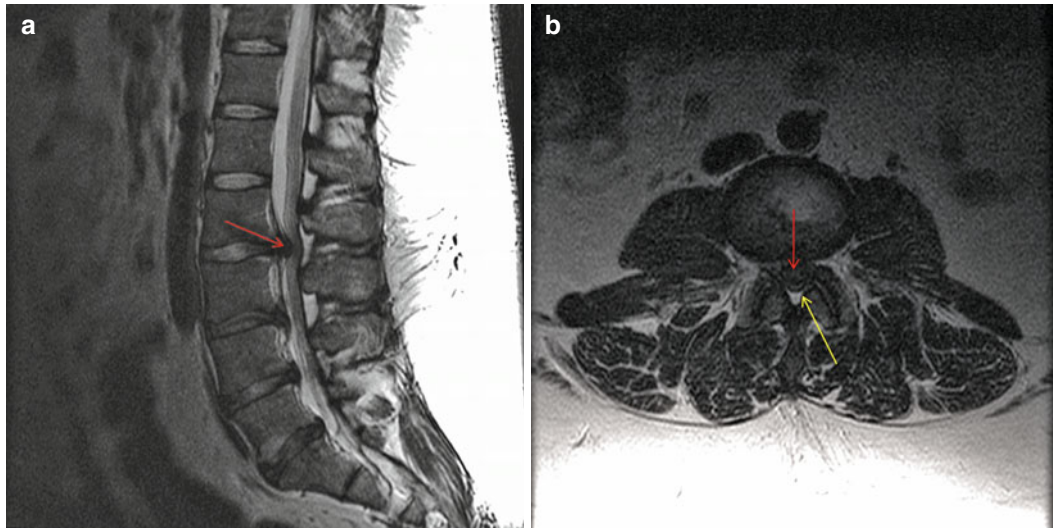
(a) Midsagittal T2-weighted MRI in a 28-year-old male at L2–3 with the insidious onset of bilateral lower extremity weakness/numbness/tingling while erect consistent with neurogenic claudication. *Red arrow* denotes large central disc herniation displacing the thecal
